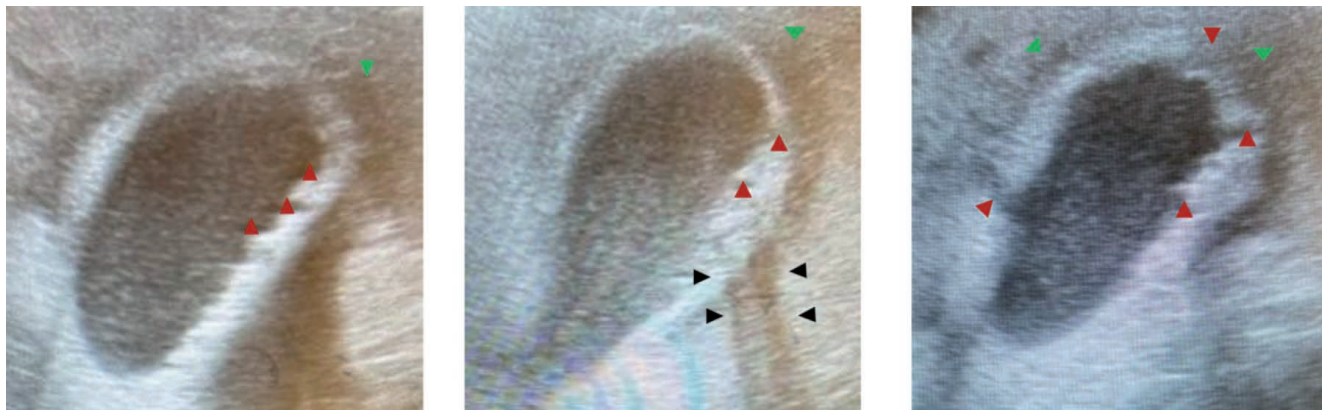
Images from the informal ultrasound performed by the surgical residents in the department. In red arrowheads, the irregularities in the gallbladder wall, in green, the pericholecystic effusion, and in black, the posterior acoustic shadowing.
